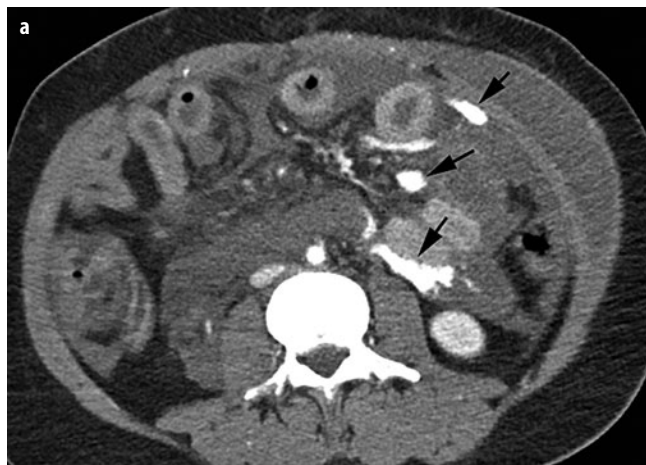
a, b. Severe mesenteric injury in a pedestrian who was hit by a motorcycle. a Transaxial and b coronal computed tomography (CT) images demonstrate hemoperitoneum and multiple areas of active extravasation (arrows) within the small-bowel mesentery
